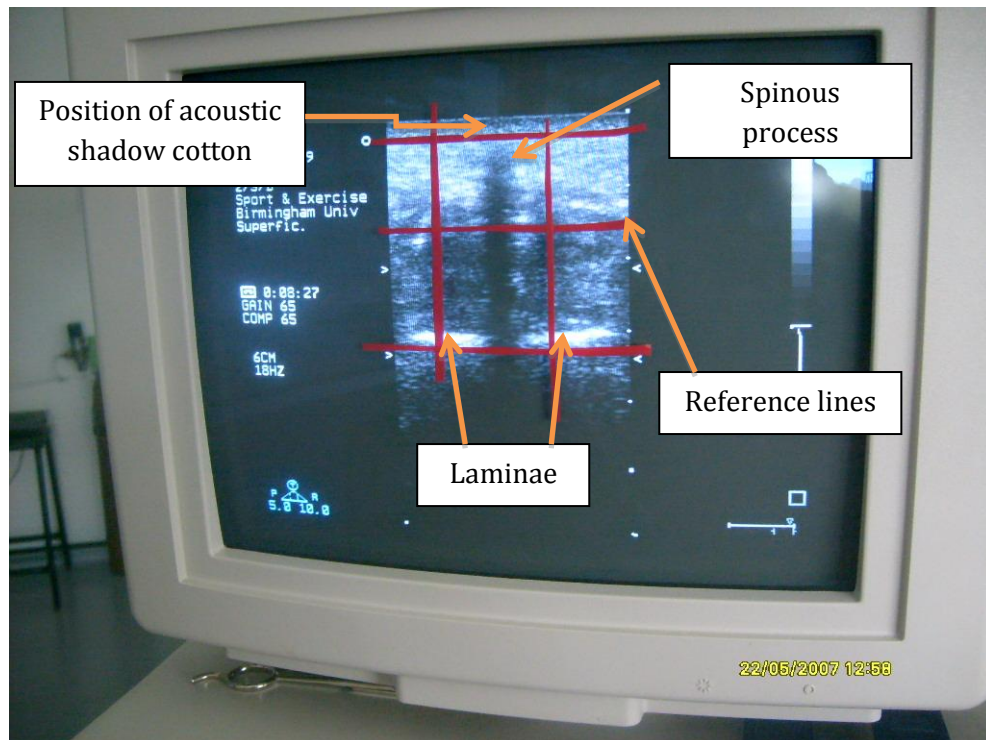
Ultrasound image of spinal vertebrae with laminae clearly visible
